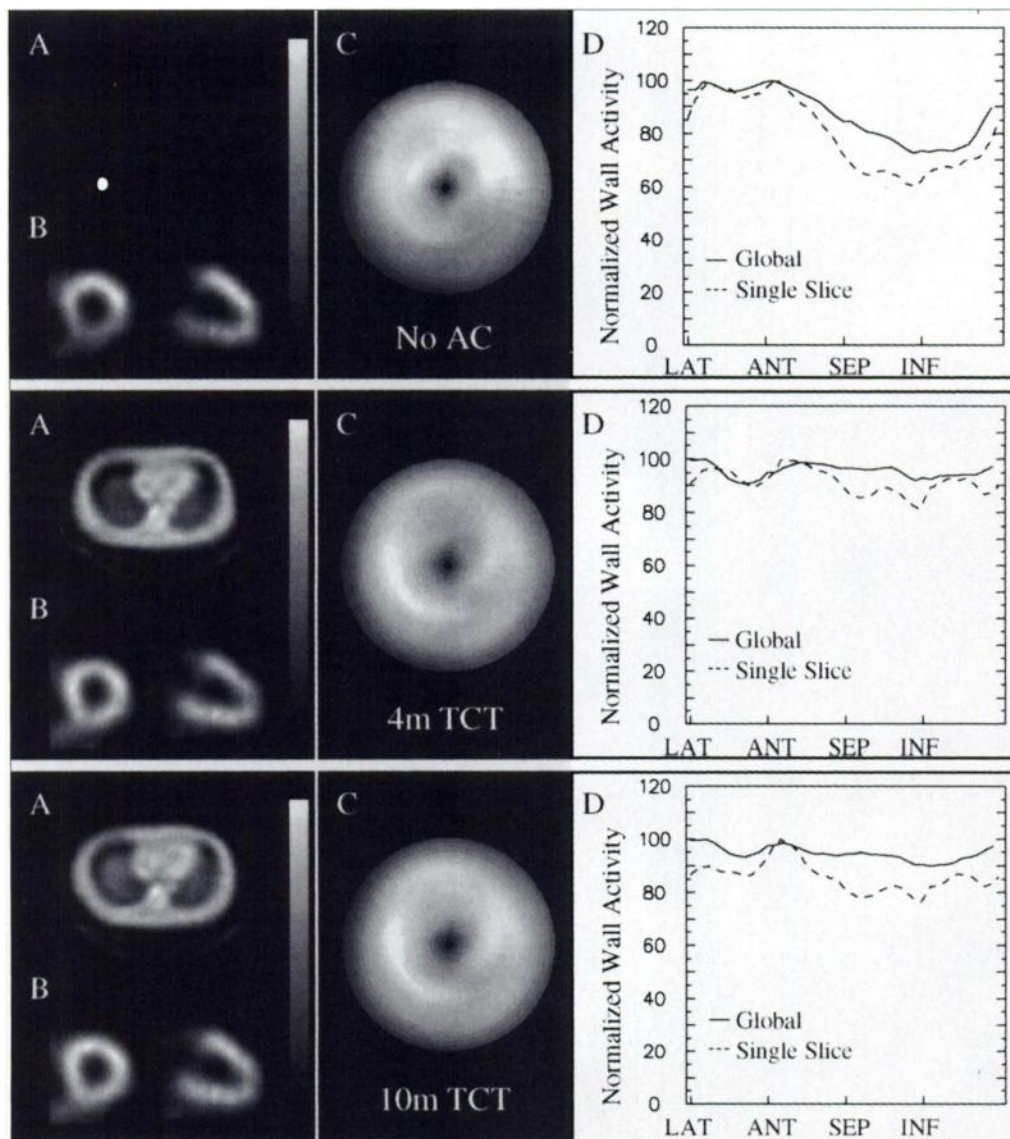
Results of NC and AC stress ^{201}Tl SPECT imaging for Patient 2. This individual was a 37-yr-old man who complained of chest pain but had no other clinical evidence of cardiac disease. (A) Single-pixel-thick slice of TCT. (B) Short-axis and vertical long axis slices of portion of myocardium that demonstrates most significant attenuation on NC study. (C) Polar map of SPECT data. (D) Summed circumferential profiles for SA slice shown in B and for myocardium as a whole (global profile).
